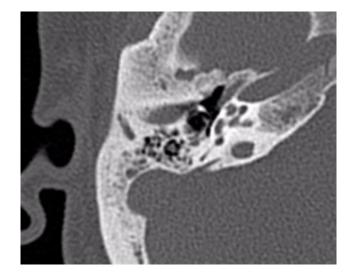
CT scan of the right internal auditory canal - axial view. After receiving the treatment course.
